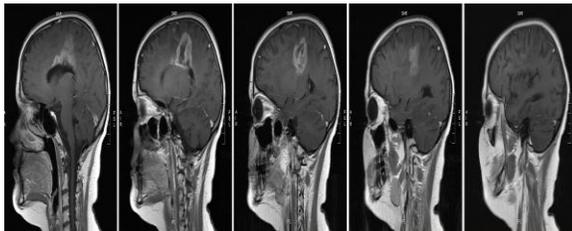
MRI Images of same patient taken at different angles at first month
